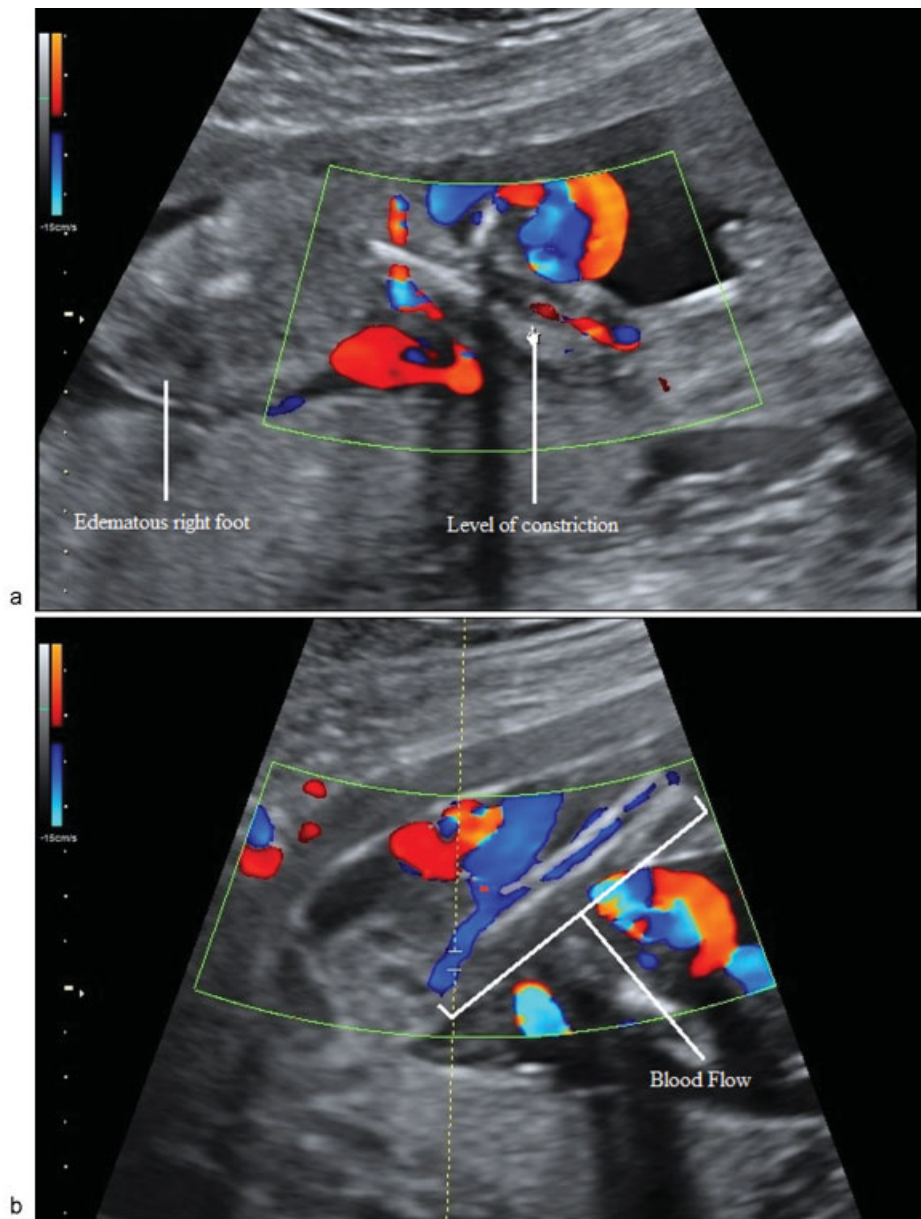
Preoperative ultrasound images of the right and left lower extremities. (a) Right leg with no evidence of color Doppler waveforms distal to the constriction bands. (b) Color Doppler waveforms present along the entire length of the left lower extremity (bracket).
